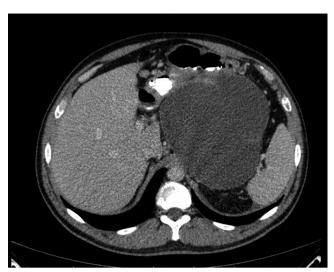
CT image of the retroperitoneal abscess (transversal section)
